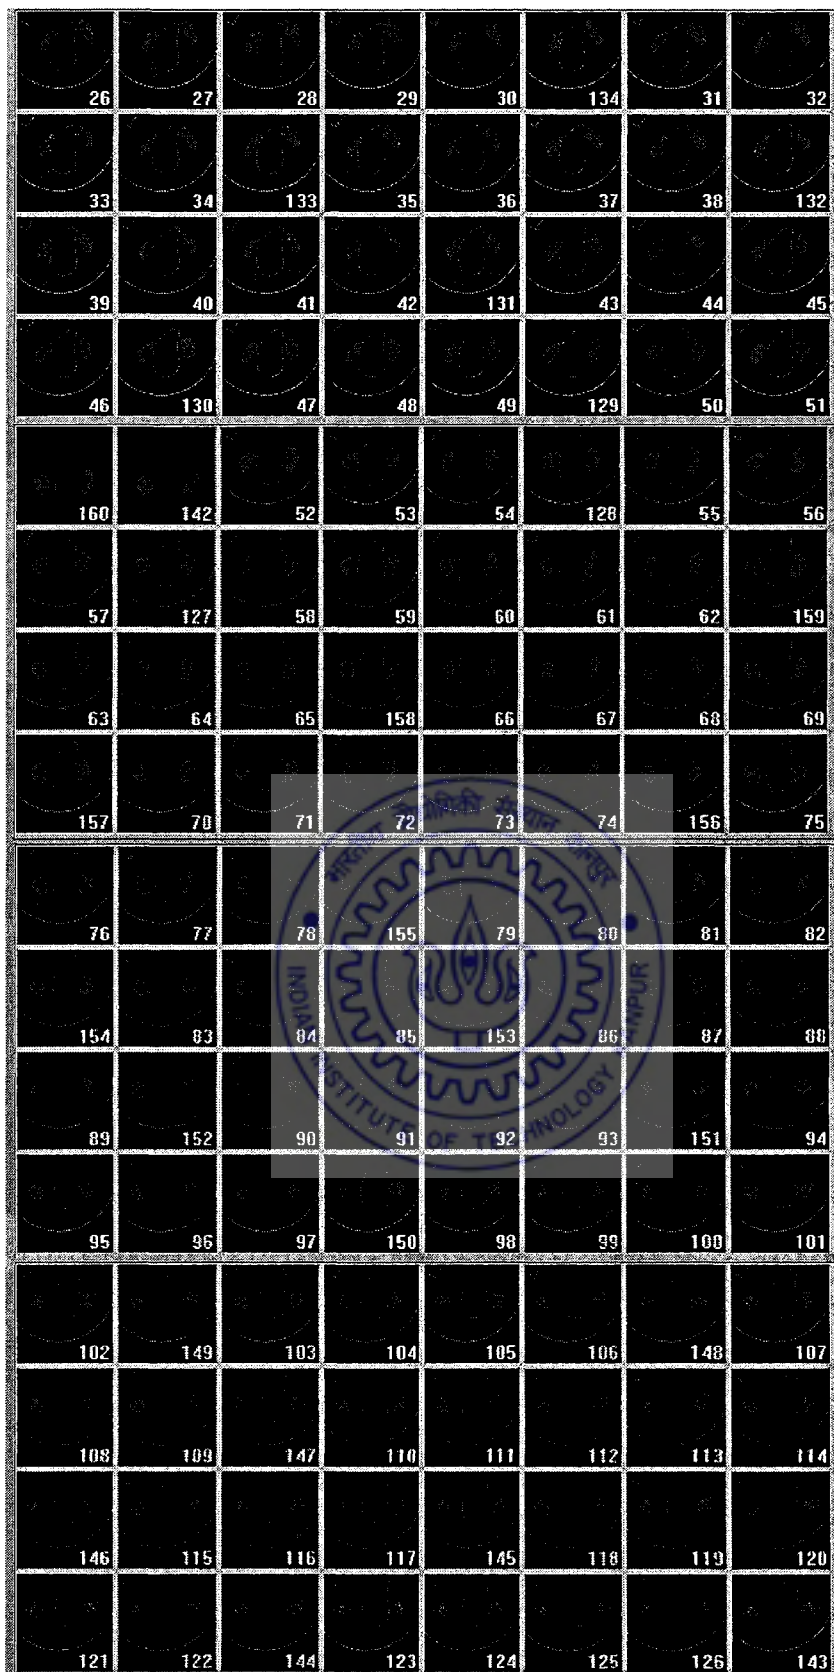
MRI scan data of clubfoot of Patient V
